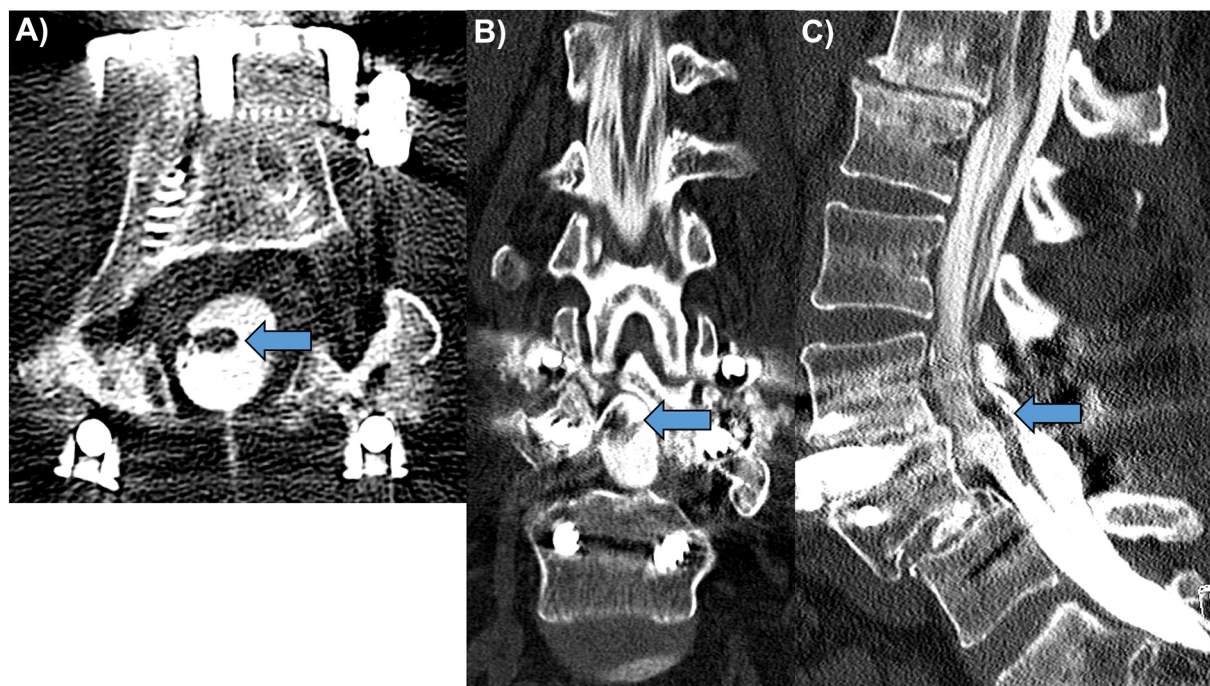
Axial (A), coronal (B), and sagittal (C) computed tomography myelogram showing type 2 clumping of the nerve rootlets of the cauda equina centrally within the thecal sac at the L3/4 and L4/5 spinal levels (arrows). There is a total laminectomy at L3 and L4 with a posterior pedicle screw and rod fixation of L3-L5, and an anterior screw and plate fixation of L3/4. There is persistence of the post-traumatic L4/5 spondylolisthesis following posterior surgical fixation.
